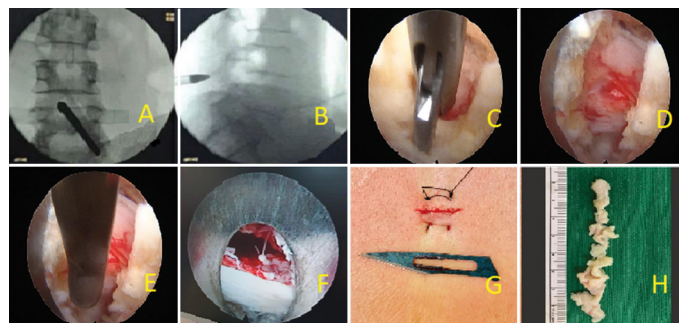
Percutaneous endoscopic interlaminar discectomy. (a) The entry point in the anteroposterior radiographic view at the L4-L5 level. (b) Dilator is positioned above the articular processes, considering the insured limit in the lateral radiographic view so as not to invade the canal. (d) Visualization of the epidural space. (e) Removal of the nerve root. (f) Visualization of the neurological structures with identification of the root axilla. (g) Surgical scar. (h) Disc material removed. Source: The author (2021).
